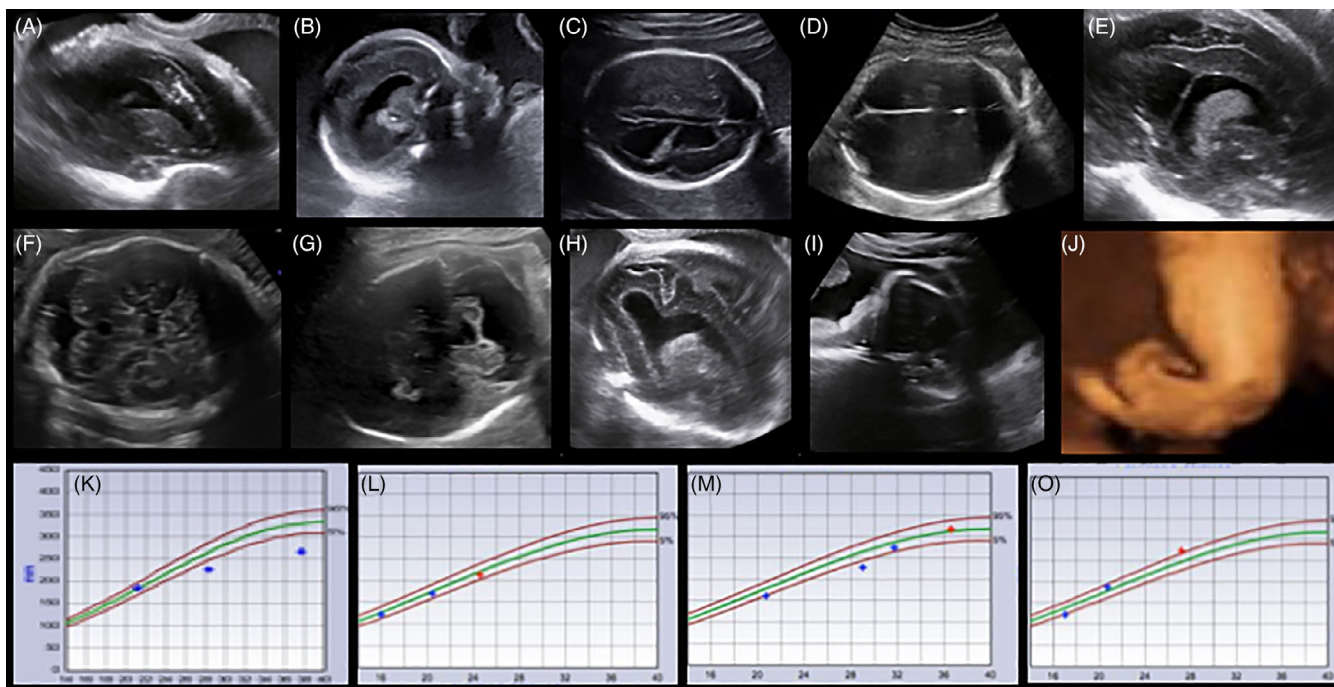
Neurosonography findings in cases of congenital Zika syndrome (CZS). A, Subcortical calcifications; B, calcifications in the basal nuclei; C, mild ventriculomegaly; D, severe ventriculomegaly; E, ventriculomegaly with intraventricular adhesion; F, normal cerebellum; G, cerebellar and vermis hypoplasia, widening of the posterior fossa; H, delay in cortical development, ventriculomegaly; I, collapse of the bones in the skull; J, arthrogyposis; from K-N, growth pattern of head circumference (HC) [Colour figure can be viewed at wileyonlinelibrary.com]
